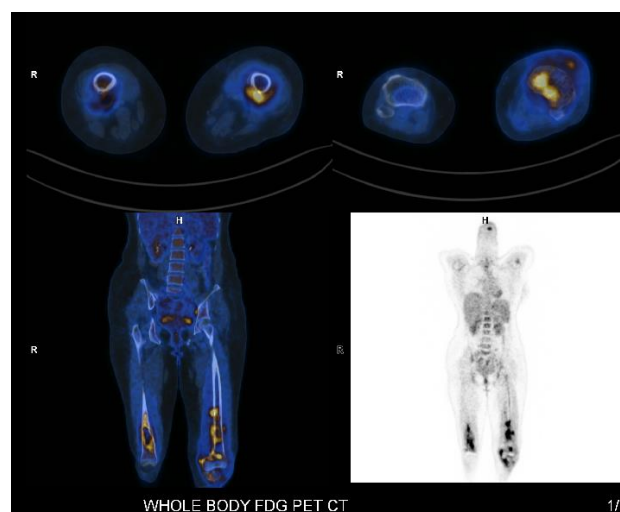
Whole body PET CT; diffuse heterogeneous uptake in distal 1/3rd of bilateral femori and proximal 1/3rd of left tibia-suggestive of osteomyelitis.
